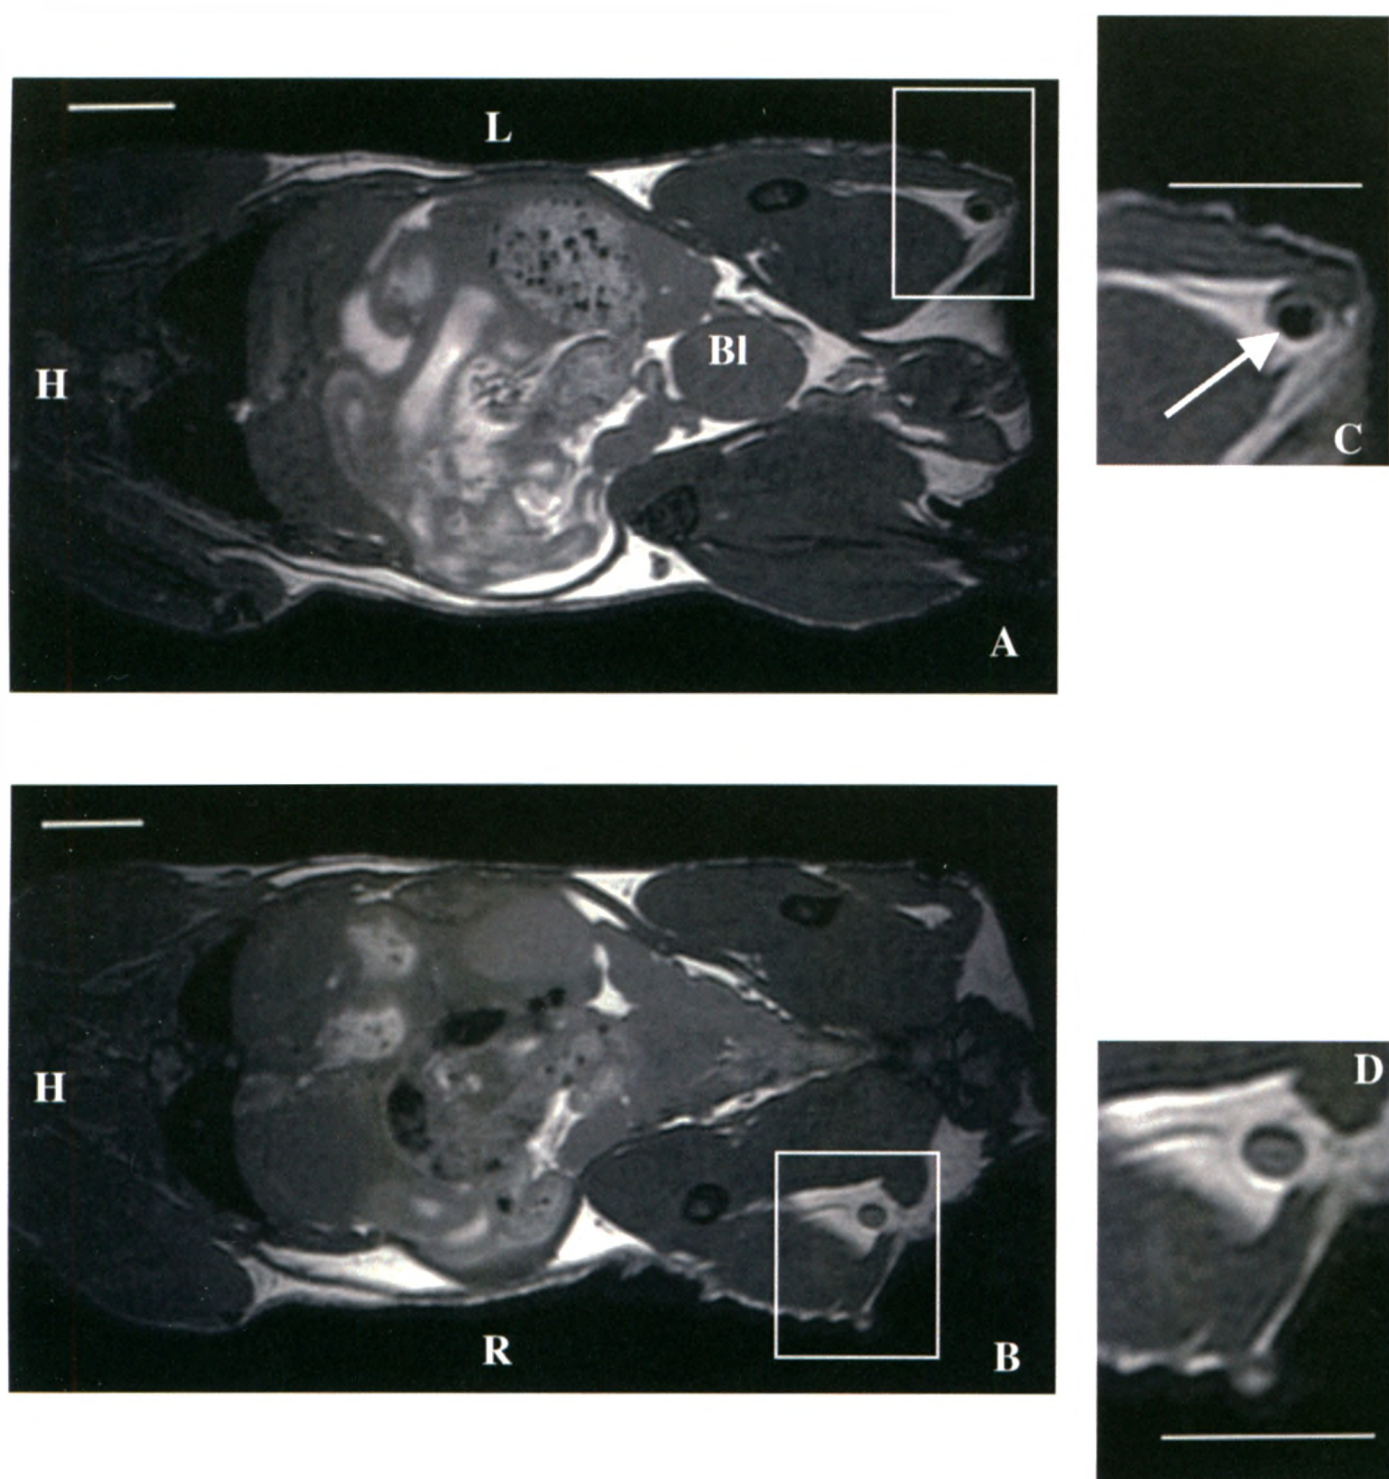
In vivo 3DFIESTA coronal MR images of lymph nodes. (A) Left lymph node after injection of  $1 \times 10^6$  MPIO-labeled DC. (B) Right lymph node after injection of  $1 \times 10^6$  unlabeled DC. (C) Cropped and enlarged image of the left lymph node (white box in A). (D) Cropped and enlarged image of the right lymph node (white box in B). A small black area is visible in both C and D, likely representing a lymph vessel. Scale bar = 5 mm.
